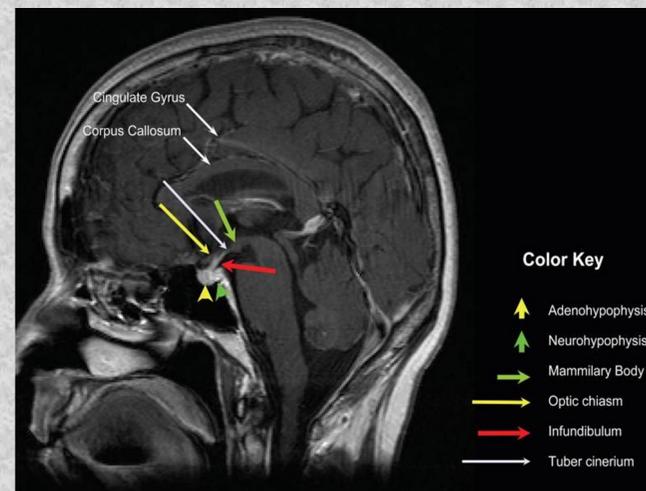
Sagittal post-contrast, T1-weighted MRI, demonstrating normal adult anterior and posterior pituitary gland and sellar region anatomy.⁵
